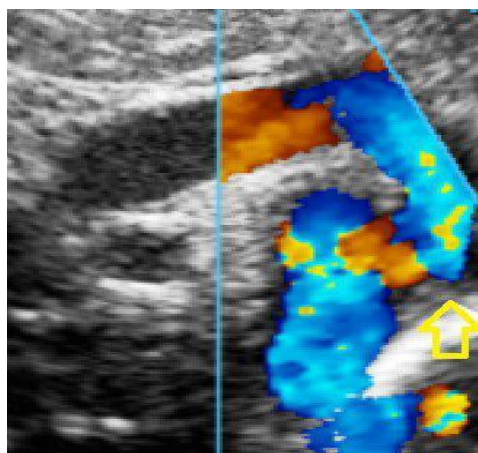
color Doppler echocardiography showed flow acceleration in stenotic portion of DAO.
